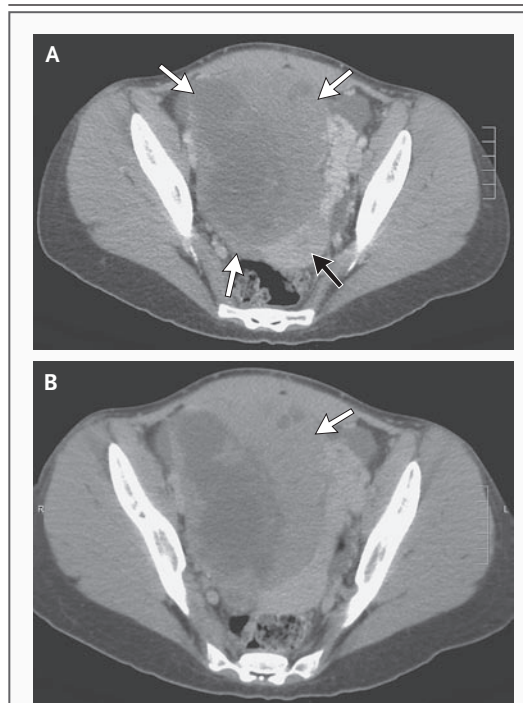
CT of the Pelvis with Intravenous and Oral Contrast.
